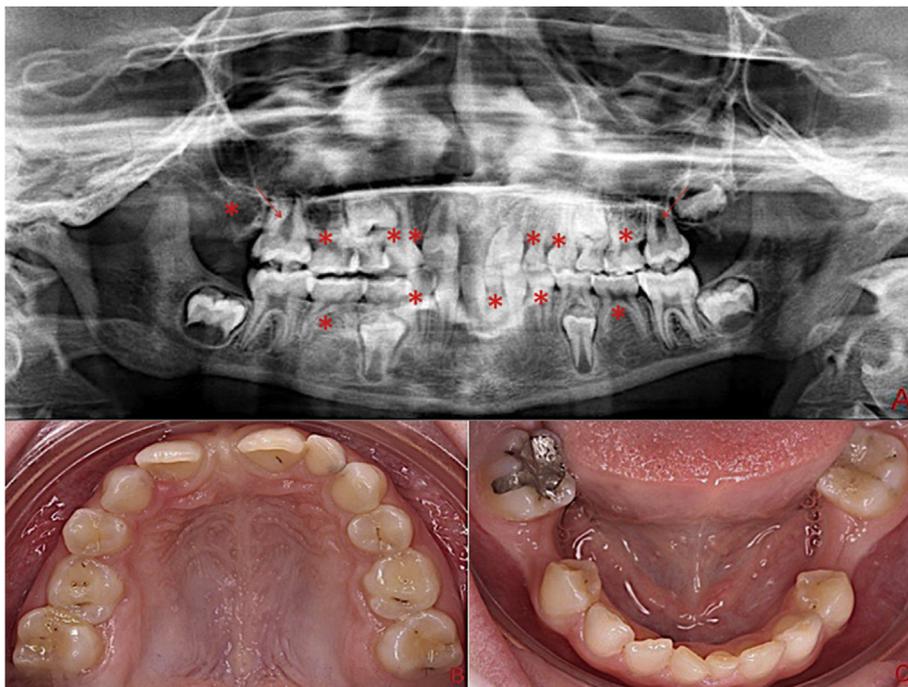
Patient 4 at 8 years old. A: Panoramic radiography; B: Maxillary clinical view; C: Mandibular clinical view.
